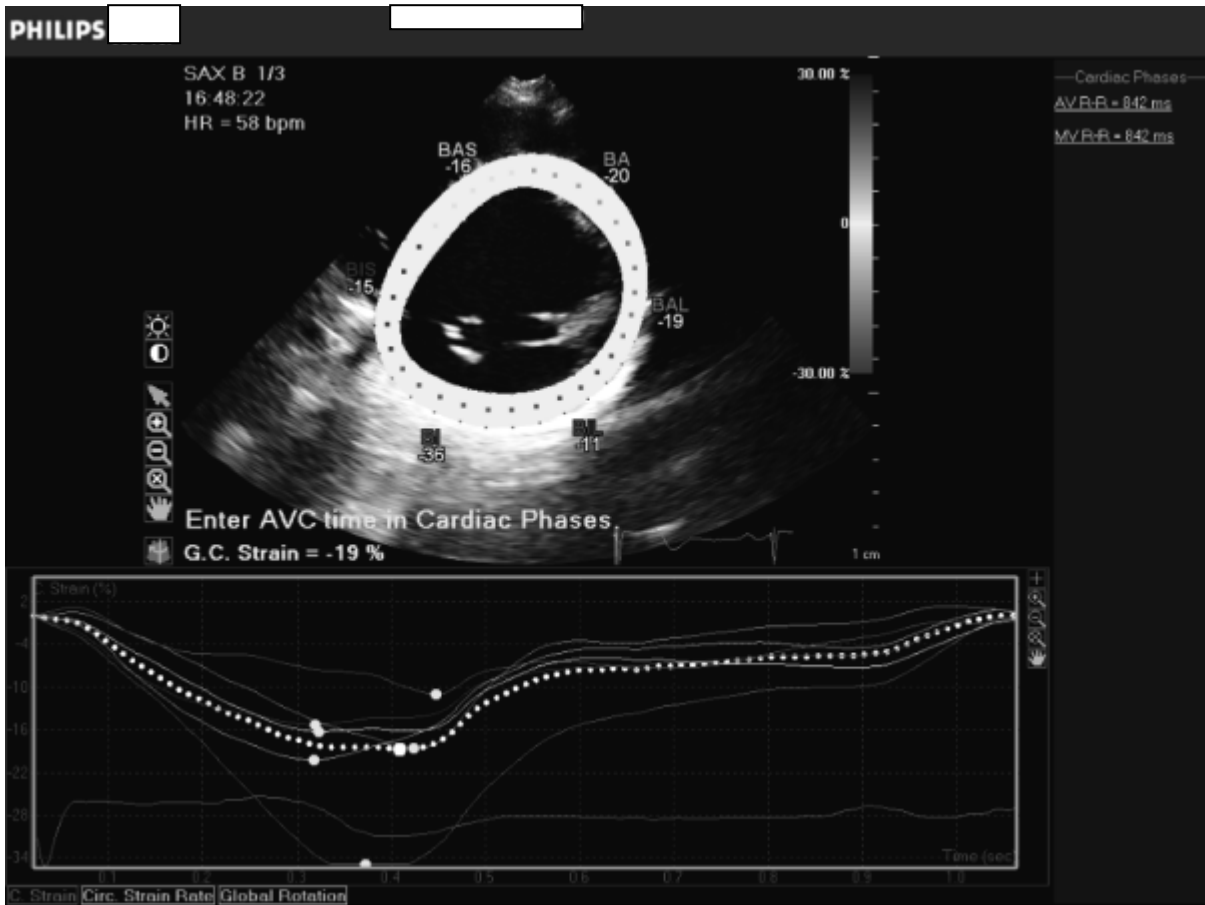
Parasternal short axis view for global circumferential strain
